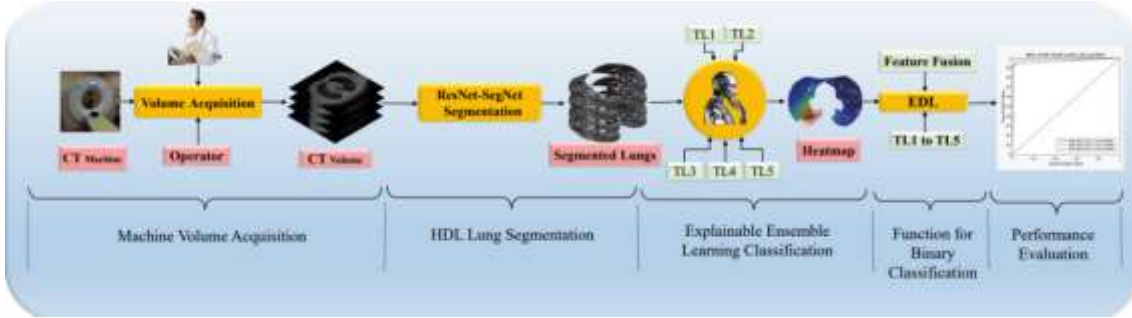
COVLIAS 3.0_{XEDL}: CT volume acquisition, ResNet-SegNet-based segmentation, TL-based feature extraction and explainability, and feature fusion-based EDL classification.
